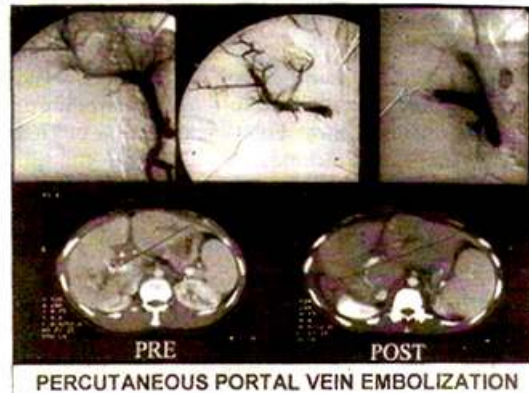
Right portal vein embolization with multiple steel coils (A, B) after percutaneous puncture under ultrasound guidance. Pre (C) and one week post (B) embolization computed tomogram show enlargement of left lobe of liver
